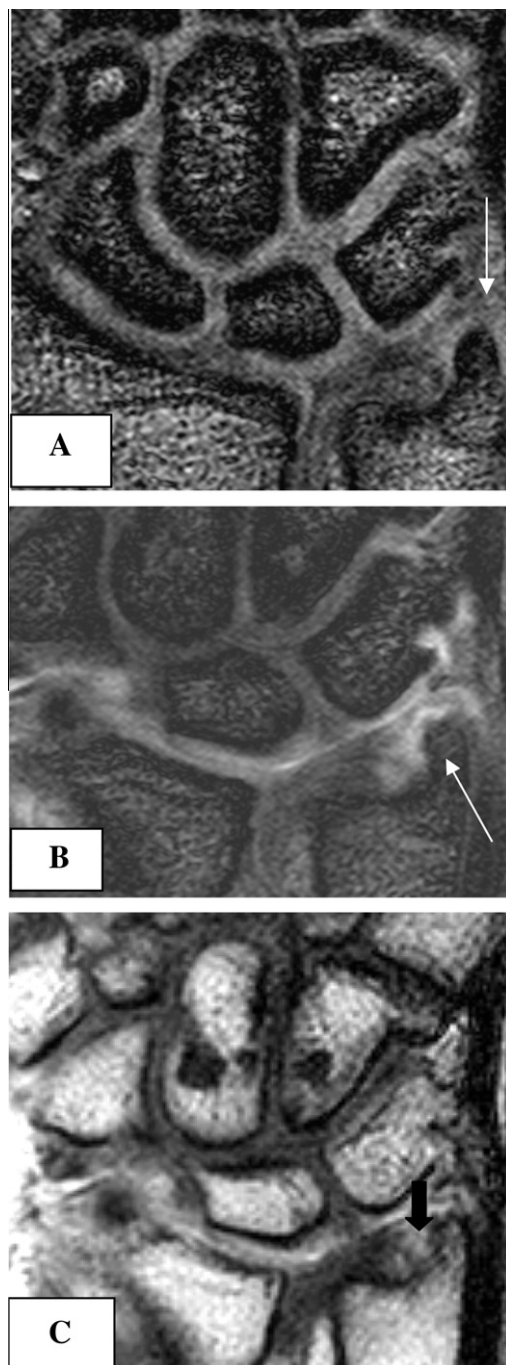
Male patient was complaining of chronic right sided ulnar wrist pain, he had a history of old trauma to the wrist and underwent conventional MRI. Coronal T2 3D FFE WIS (A) revealed: detachment of the peripheral attachment of the TFC to the ulnar styloid (arrow). Single intra articular injection into the radio-carpal compartment was done, followed by MRA. Coronal T1 3D FFE & T1 MR arthrographic images (B & C) confirmed the presence of peripheral TFC tear at the attachment to the ulnar styloid process (white & black arrows), being outlined by the injected contrast. Multiple cystic degenerations are seen within the carpal bones.
